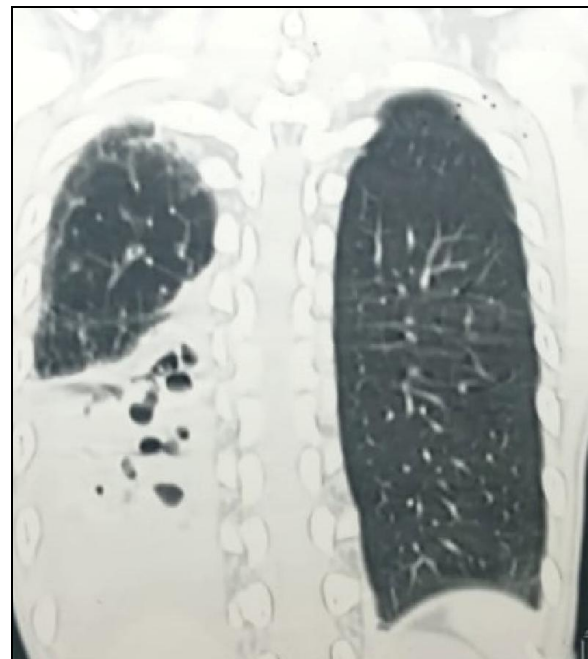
CT scan chest – preoperative
